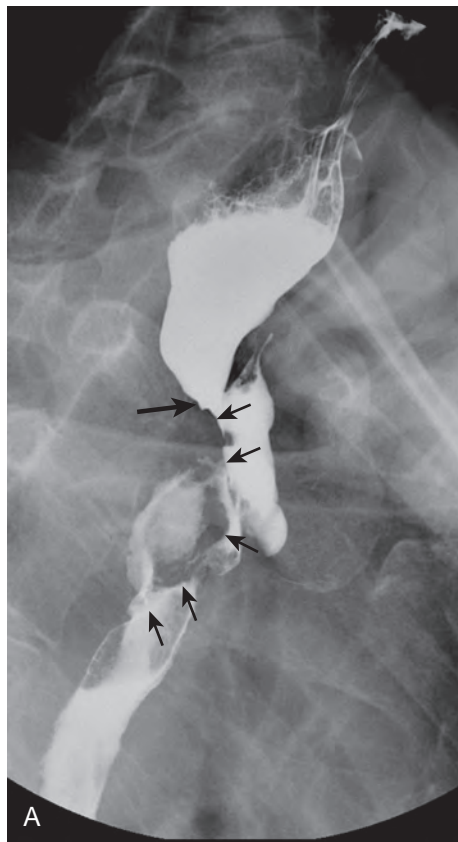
Recurrent mediastinal tumor after esophagogastrectomy. A. A large lobulated mass (short arrows) invades the postoperative stomach just below the esophagogastric anastomosis (long arrow). B. Axial image from an unenhanced CT scan shows a large mass (m) invading the posterior wall of the trachea (black arrows) and narrowing and compressing the pulled-through stomach (white arrow).
